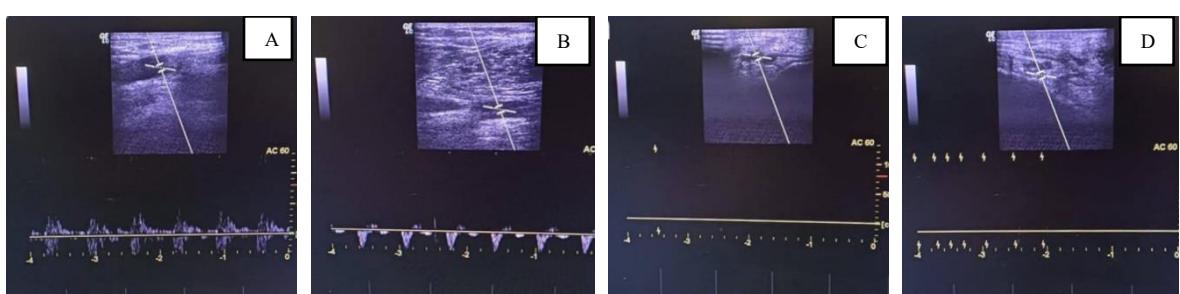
USG Doppler. A, Normal pulse on left common femoral artery with triphasic flow; B, Normal pulse on left popliteal artery with triphasic flow. C, No pulse on left dorsalis pedis artery with triphasic flow; D, No pulse on posterior tibial artery with triphasic flow
